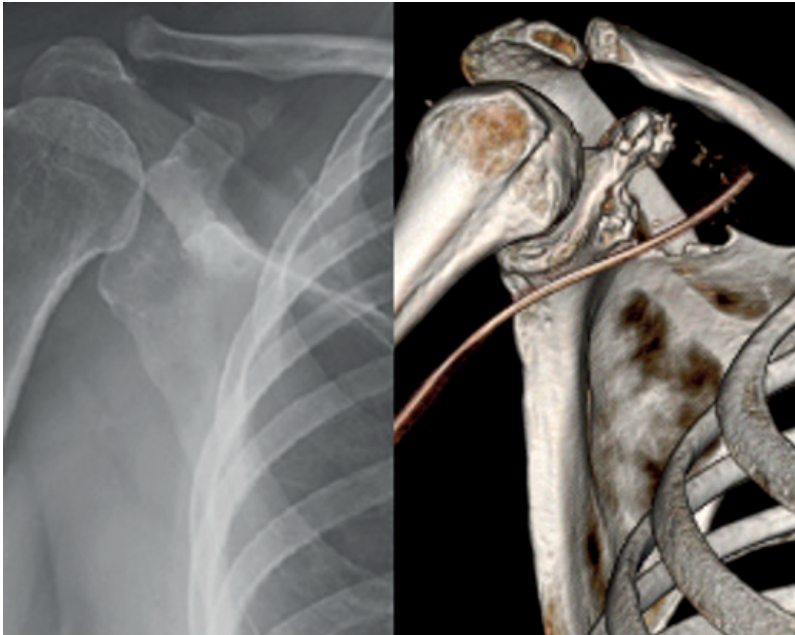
a Posterior–anterior radiograph (left) and axial computed tomography (right) of a grade 1 chondrosarcoma of the scapula before surgical resection (patient 1). b Posterior–anterior radiograph (left) and three-dimensional computed tomography (right) of the scapula after surgical resection of a grade 1 chondrosarcoma (patient 1)
